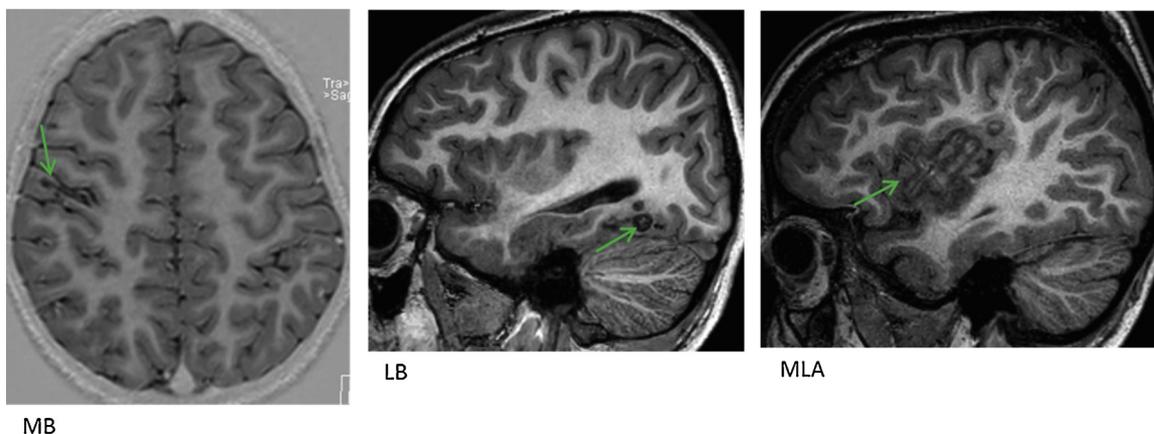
Examples of post-RFTC MRI in three different patients. Lesions are indicated with an arrow.
